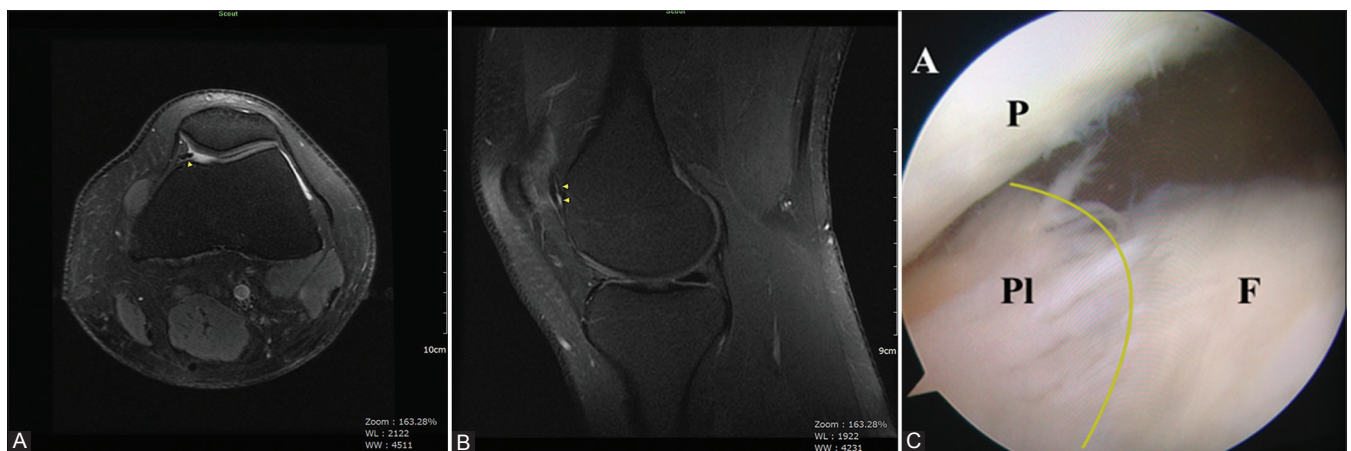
(A-C): On the fat suppressed T2WI axial sections passing from the center of the patella; (A) thick, shelf-shaped Type 3 medial plica covering the medial trochlear surface is seen in the knee with Type C trochlear dysplasia (arrow head). (B) The extension of Type 3 plica on the fat suppressed T2WI sagittal plan (arrow head). (C) In arthroscopy, thick, fringed, and shelf-shaped Type 3 medial plica partially covering the femur medial condyle was seen in line with the MRI
